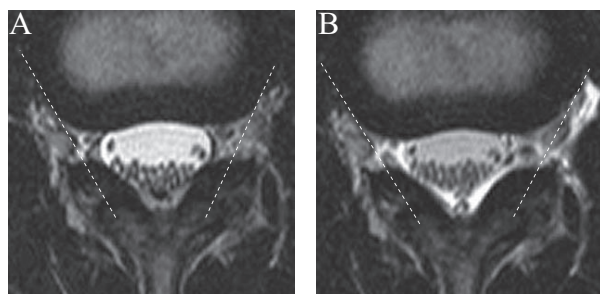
Example of the criteria line for saline leakage from the intervertebral foramina, defined as a straight line passing through the center of intervertebral joint and the point of contact with the vertebral body at disk level. The magnetic resonance images are shown for nonpregnant woman before (A) and after (B) saline injection at the L2–L3 intervertebral disk level. Saline was observed far beyond the left criteria line (i.e., leaking from the left intervertebral foramina).
